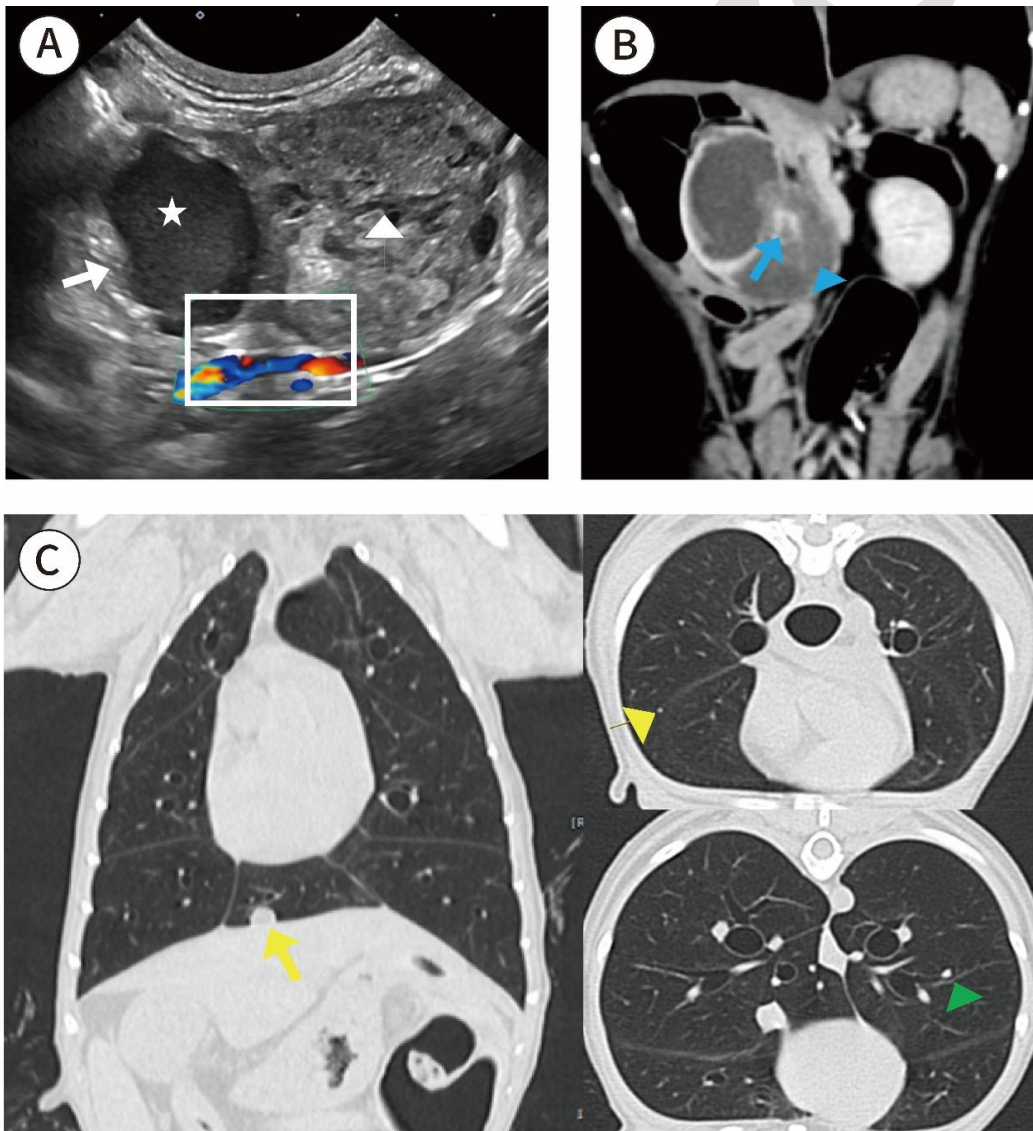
A). B-mode ultrasonography image showing a right renal mass with heterogeneous parenchymal echogenicity and irregular margins, accompanied by severe hydronephrosis (white star) and minimal residual renal parenchyma (white arrow). The mass exhibits poor vascularity and is presumed to represent a hematoma (white arrowhead). The large mass compresses the caudal vena cava (white rectangle), with no evidence of vascular invasion or thrombosis. B). Computed tomography (CT) image showing a right renal mass composed of two distinct components: an enhancing portion (102 Hounsfield units [HU]; blue arrow) and a non-enhancing portion (20HU; blue arrowhead). C). CT images of the lung showing a 5mm nodule in the accessory lobe (yellow arrow) and micronodules (yellow arrowhead and green arrowhead).
